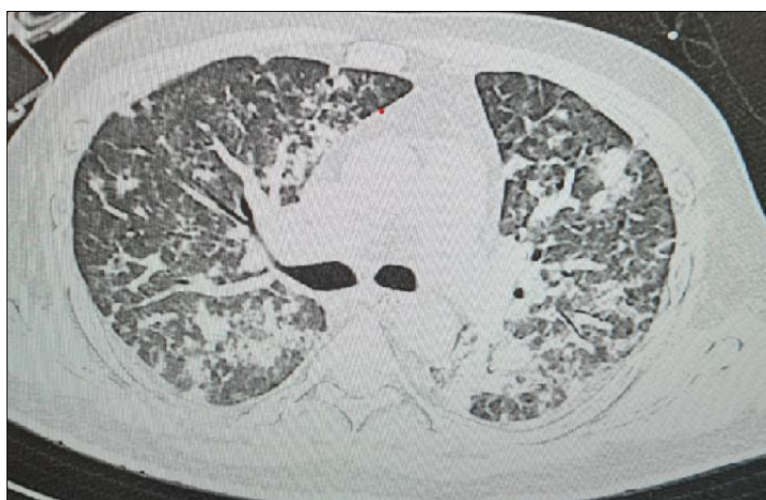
HRCT of bilateral upper lobe fibrosis, right lower lobe consolidation
